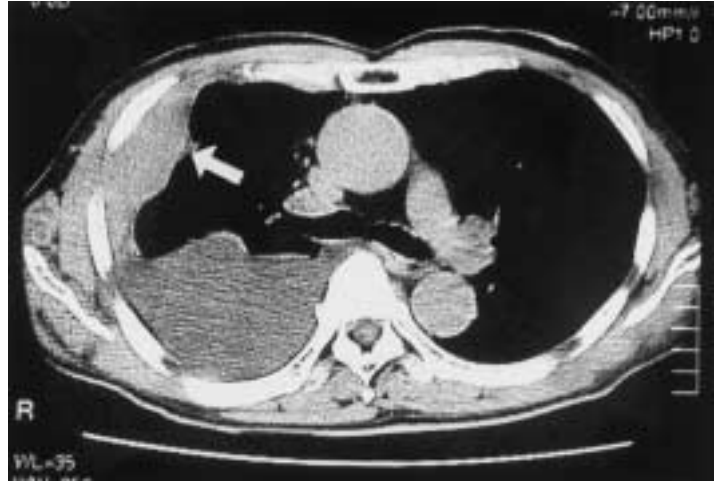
CT demonstrated a tumor (arrow) in the pleural wall with atelectasis of the middle lobe and pleural effusion on the right side, but without lymph node swelling.
